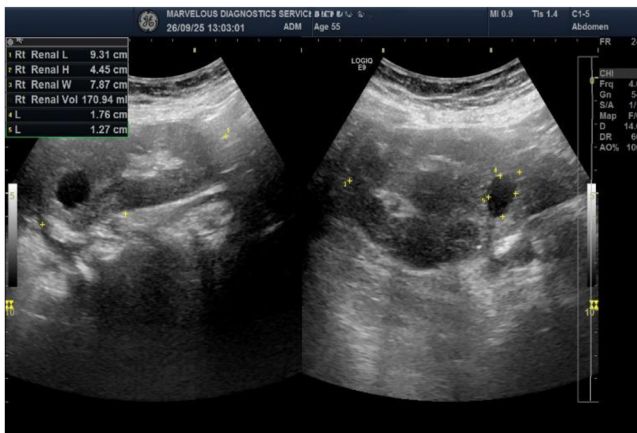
2D abdominal ultrasound image demonstrating crossed fused renal ectopia (CFRE) located in the right iliac region, with a small cortical cyst visible.
